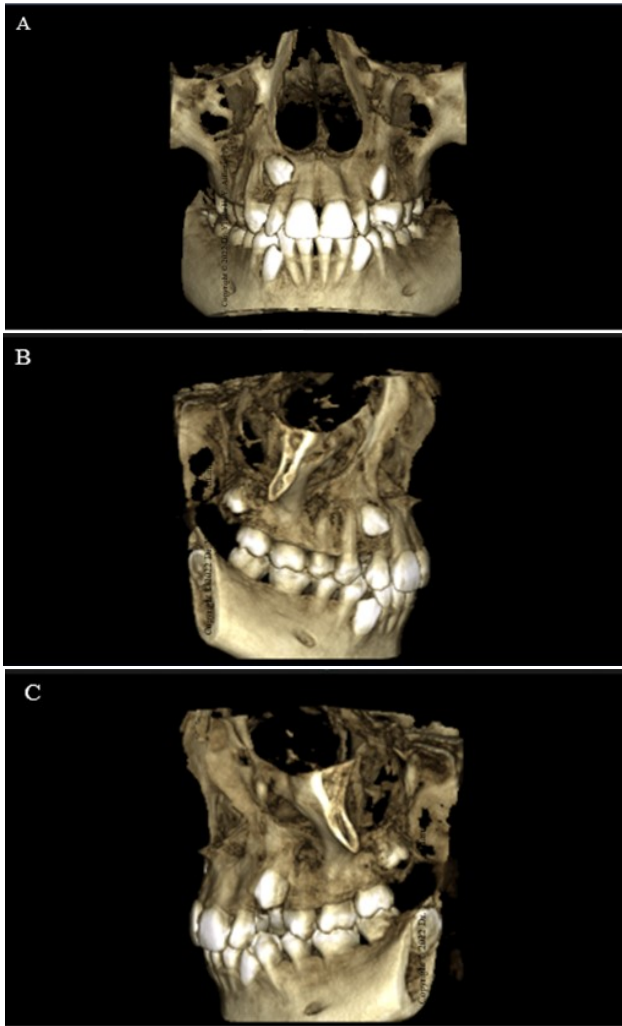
The classification of malocclusion is shown in the three-dimensional reconstructed image acquired from raw CBCT data; (A) Frontal view, (B) Right side Class I molar relationship, and (C) Left side Class I molar relationship.
